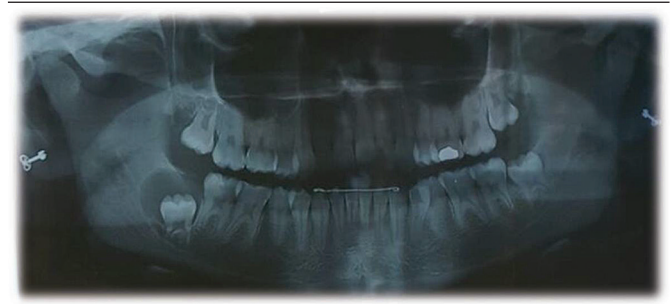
Panoramic radiograph showing radiolucent area around the tooth 48
